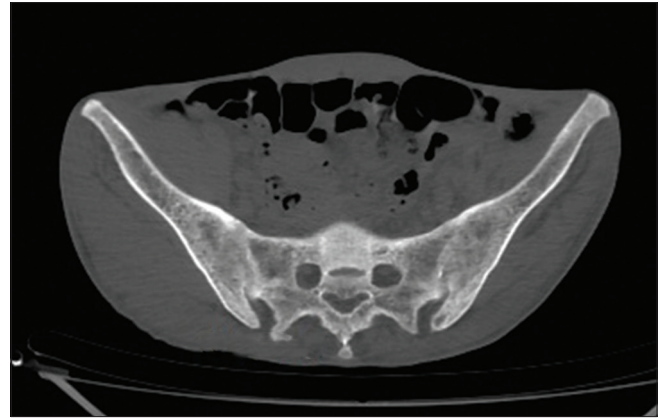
Axial CT image showing bilateral SI joint ankylosis
